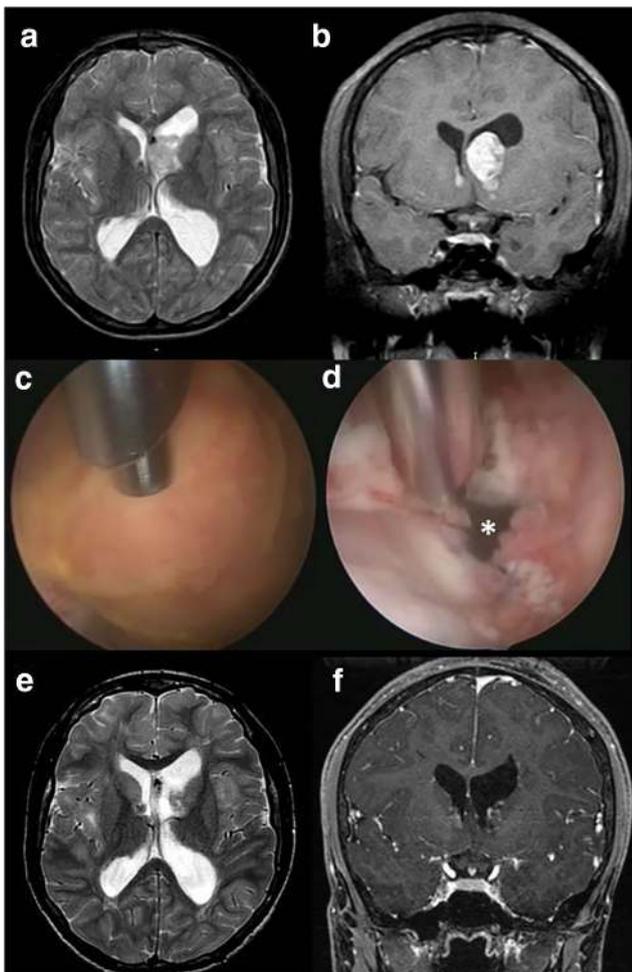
16-year-old boy with left SEGAs and progressive ventricular dilation (a, b). Tumor was resected by endoscopic approach with the aid of endoscopic ultrasonic aspirator (Sonoca®, Söring GmbH, Germany) (c), thus freeing the foramen of Monro (d, asterisk). Postoperative axial T2-weighted and coronal T1-weighted after contrast administration MR images confirming the total removal of the tumor (e and f, respectively)
